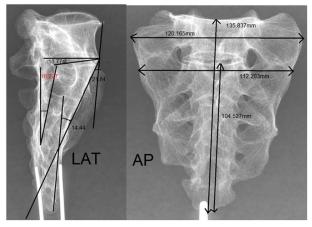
Digital X-ray of abnormal Sacrum: Lateral and AP view.
